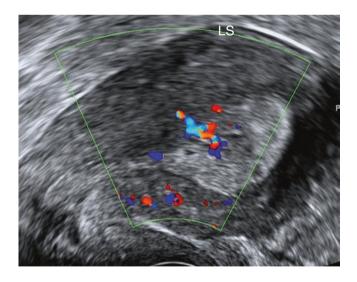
Adenomyomatous polyp. (a) Seen on greyscale. (b) Showing Doppler flow. (c) Seen at hysteroscopy
